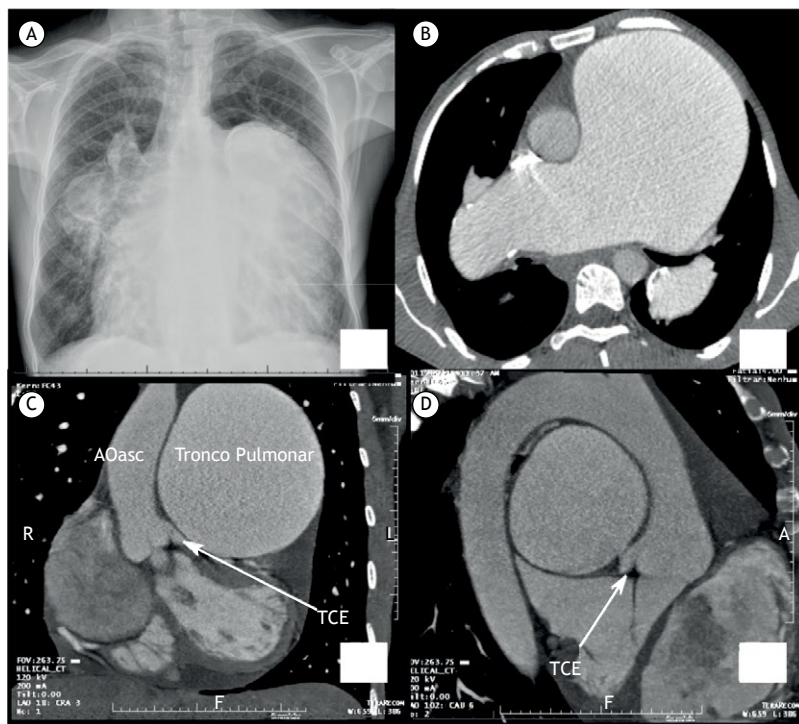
In A, chest X-ray; in B, chest CT scan showing aneurysmal dilatation of the pulmonary artery; and in C and D, CT image reconstruction showing extrinsic compression of the ascending aorta and (white arrows) by dilatation of the pulmonary artery. Designations in Portuguese: TCE, trunk of the left coronary artery; Tronco Pulmonar: pulmonary trunk; and AOasc: ascending aorta.
